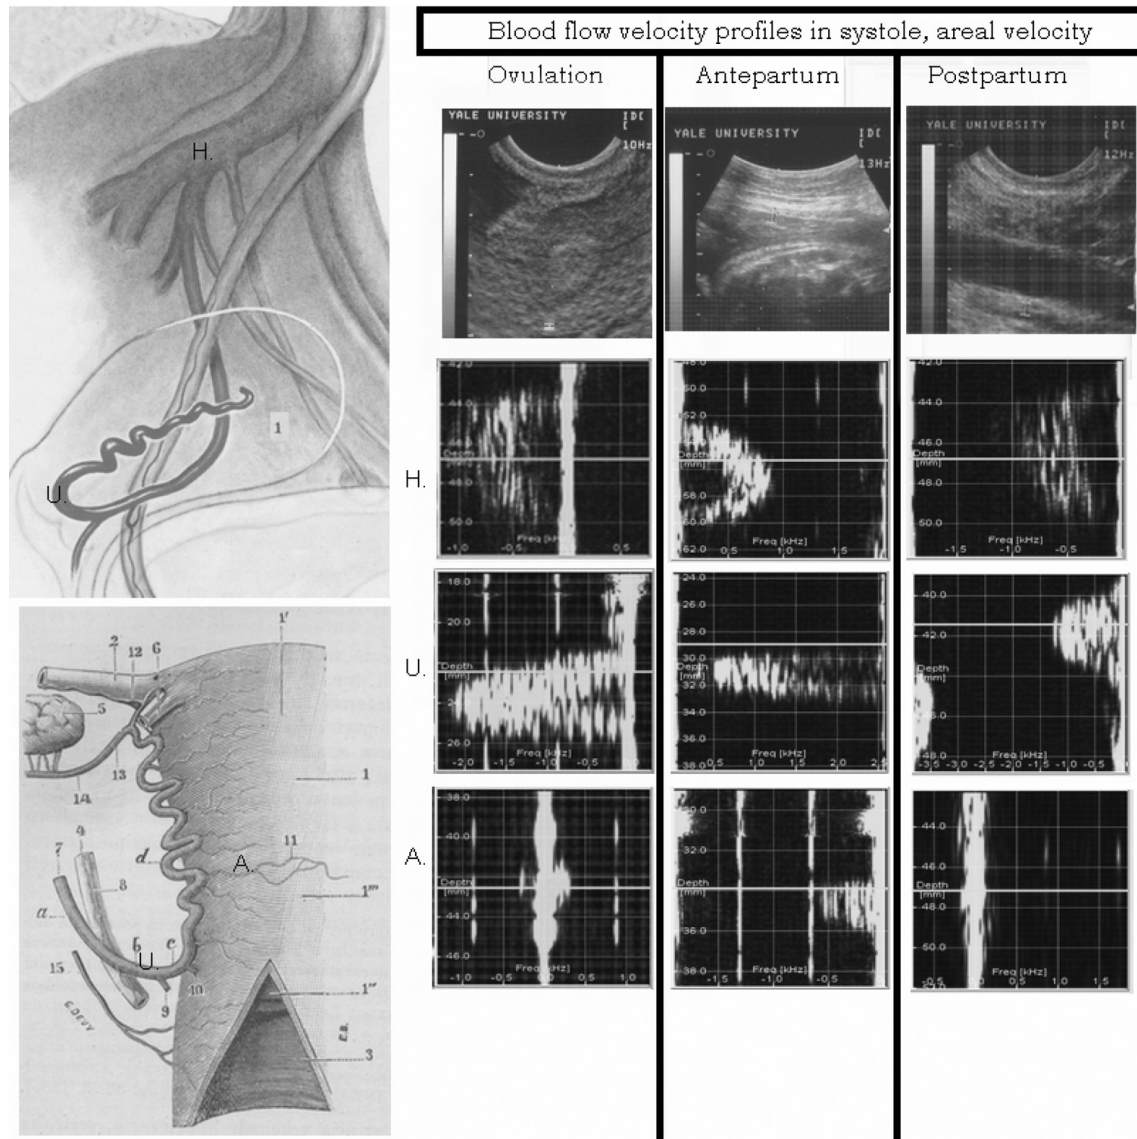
Multigate spectral Doppler analysis using GASP software for areal velocity in women at the ovulation phase of the normal menstrual cycle, in the antepartum phase of labor and at 1 h postpartum. In each column, the first image is the conventional bidimensional image of the area of interest during multigate acquisition, the following from top to bottom are hypogastric (H) artery velocity profile (areal flow), uterine (U) artery velocity profile (areal flow), and arcuate (A) artery velocity profile (areal flow). All images are frozen in systolic peak
